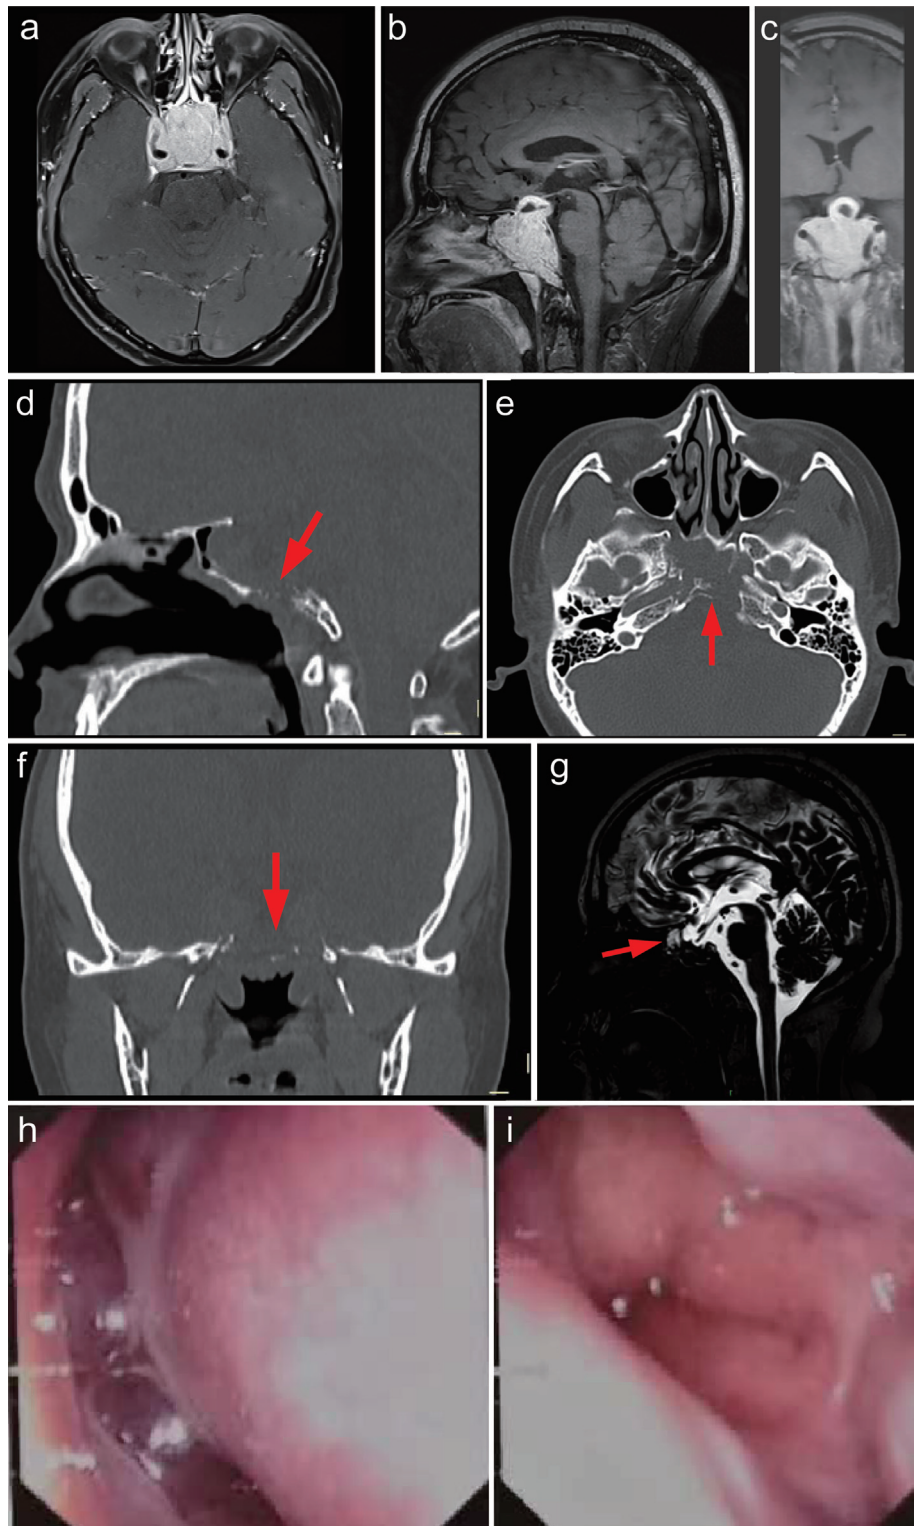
Preoperative imaging and endoscopic findings. MRI shows a mass (approx. 47×39×44 mm) with marked enhancement in the sphenoid sinus and sellar region. The lesion elevates and displaces the pituitary stalk to the right, pushes the optic chiasm superiorly, and encases both bilateral cavernous sinuses along with segments C4–6 of the internal carotid arteries (a, b, c). CT reveals bony destruction of the clivus, sellar floor, and sphenoid sinus walls (d, e, f, *red arrows*). CSF hydrography demonstrates a small patch of high signal intensity in the left sphenoid sinus, suggestive of communication with the suprasellar cistern, which confirms that CSF rhinorrhea has led to intracranial infection (*g red arrow*). Nasal endoscopy shows copious secretions in the left olfactory cleft and pulsatile discharge from the left sphenoid sinus ostium (h, i). CSF, cerebrospinal fluid; CT, computed tomography; MRI, magnetic resonance imaging.
